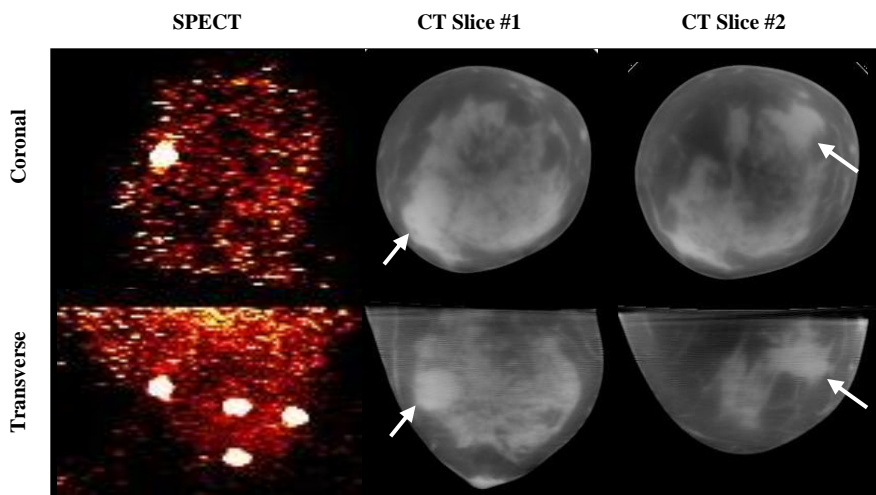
Reconstructed images of the (LEFT) SPECT (shown as a MIP image), (MIDDLE) CT Slice #1, and (RIGHT) CT Slice #2 of the left breast. Although there was no visible tumor uptake of the radiotracer in the SPECT image, there were two suspected lesions seen in the CT images (shown by white arrow). The bright white spots on the SPECT images are the fiducial markers seen in the MIP images.
